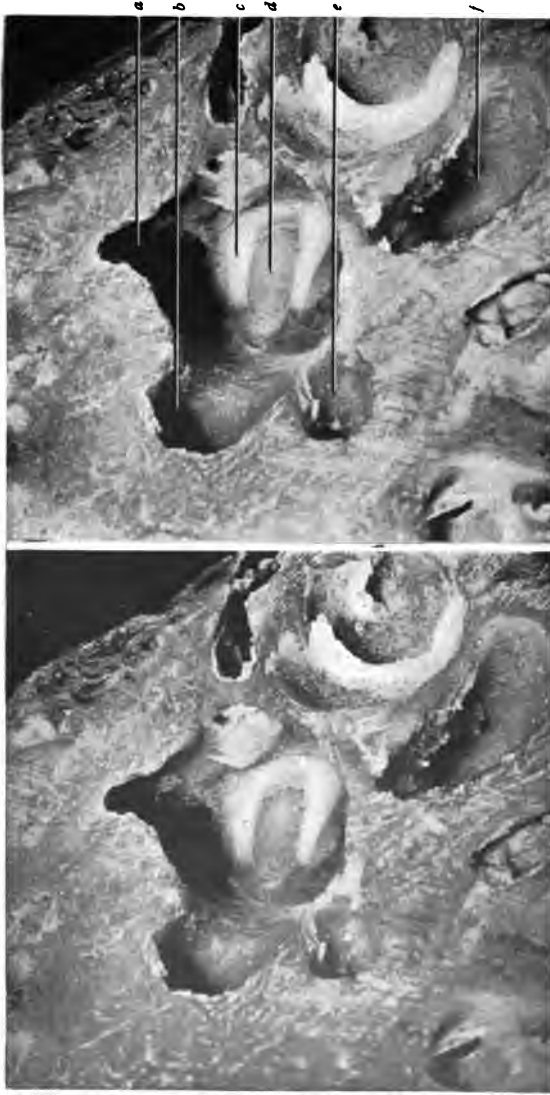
THE OUTER PORTION OF THE VESTIBULE FROM THE SAME CASE AS SHOWN IN FIG. 111: VIEWED FROM THE INNER ASPECT AND BEHIND. X 5.
